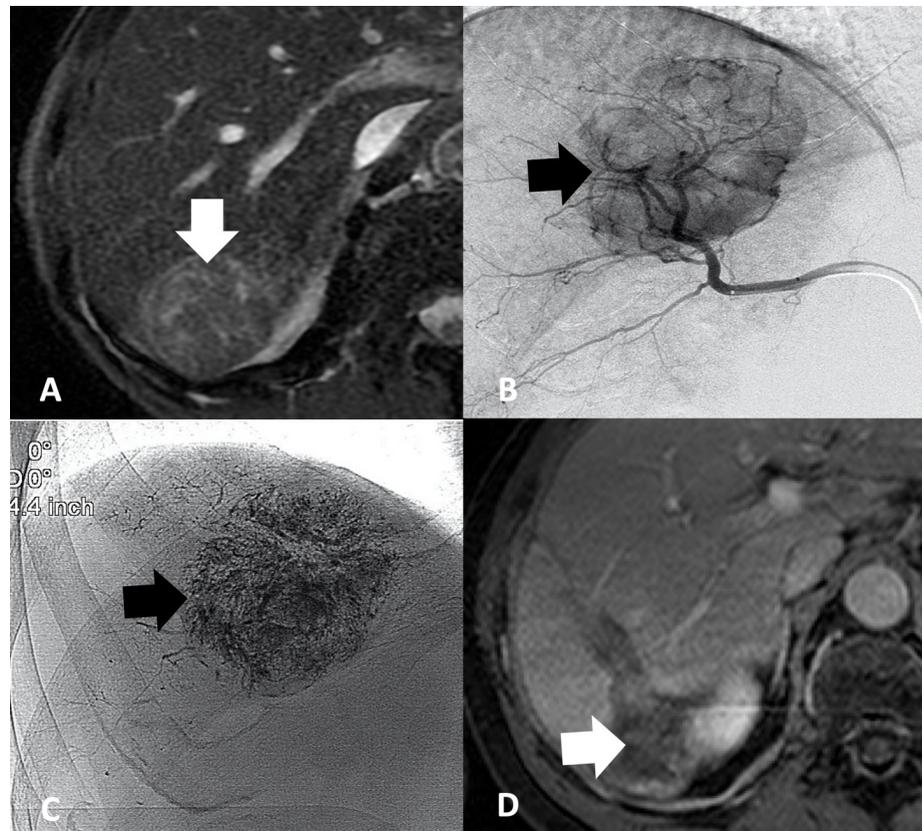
A 69-year-old man with cirrhosis secondary to hepatitis C. (A) Axial slice from a T2-weighted magnetic resonance imaging (MRI) scan demonstrates a well-defined, hyperintense mass in the right lobe of the liver (white arrow), measuring >5 cm. Prior to treatment, the patient was outside of Milan criteria. (B) Digital subtraction angiography from the right hepatic artery during conventional transarterial chemoembolization (cTACE) procedure demonstrates the hypervascular mass in the right lobe of the liver (black arrow). (C) Radiograph obtained after cTACE demonstrates excellent uptake of ethiodol/doxorubicin within the mass (black arrow). (D) Axial slice from a T1-weighted MRI scan after contrast administration in portal venous phase demonstrates no residual enhancement within the mass, consistent with a complete response to therapy and successful downstaging of the patient to be within Milan criteria. The patient underwent transplantation approximately 14 months after this MRI scan was obtained.
